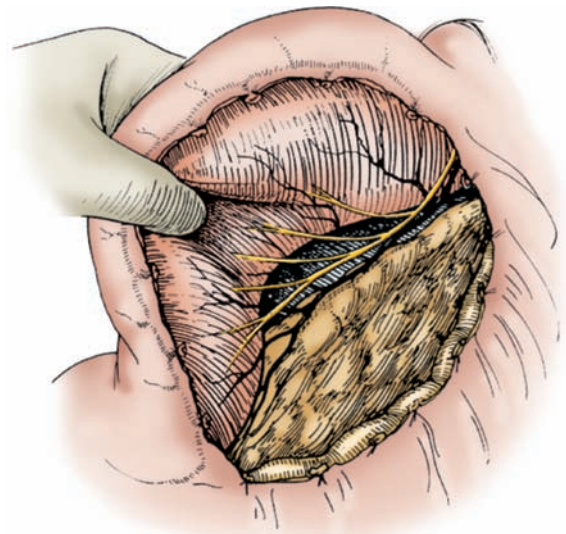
The posterior wall of the stomach and posterior nerve of the Latarjet are shown. The terminal Y fork of the nerve is preserved, and all of the branches to the stomach are divided, leaving about 5 cm of the distal portion of the stomach innervated. (Redrawn, with permission, from Johnston D. Vagotomy. In: Schwartz SI, Ellis H, eds. *Maingot's Abdominal Operations*. 8th ed. Norwalk, CT: Appleton-Century-Crofts; 1985. After R.N. Lane.)
